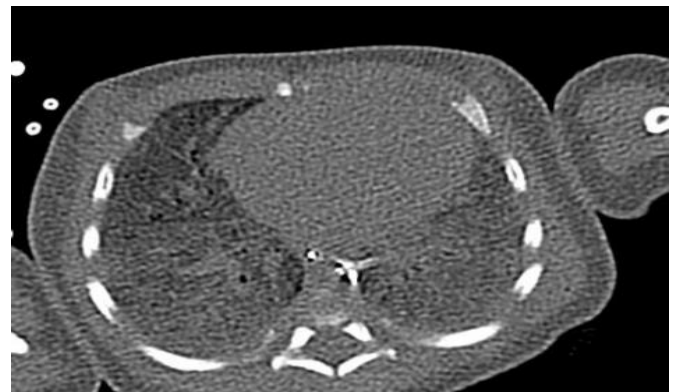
Non-contrast CT axial view in lung and mediastinal window showing ground glass appearance of bilateral lungs
